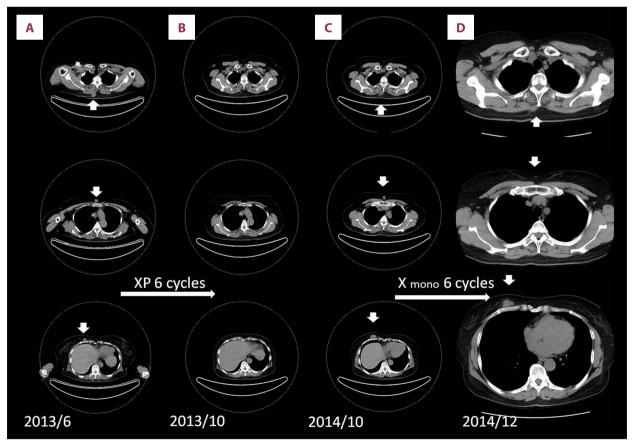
(A, B) Chest computed tomography (CT) scans, which followed after 6 cycles of XP (capecitabine and cisplatin) chemotherapy showed disappearance of multiple subcutaneous metastatic nodules (white arrows). (C, D) Chest CT following capecitabine monotherapy revealed no interval change of regrown metastatic nodules.
